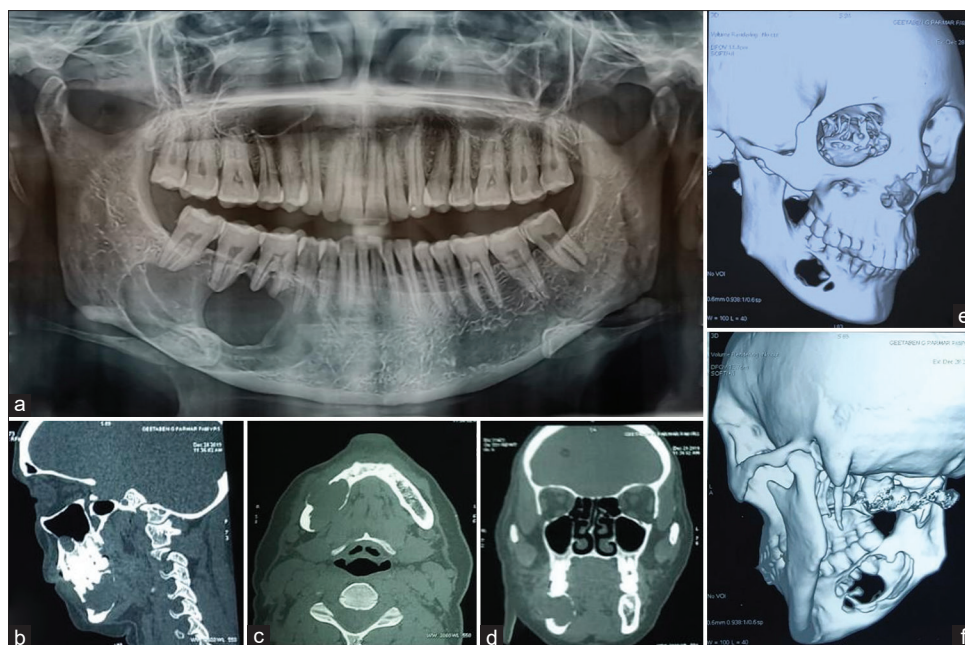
Preoperative radiographs. (a) OPG (b) Sagittal view (c) Axial view (d) Coronal view (e, f) 3D views
